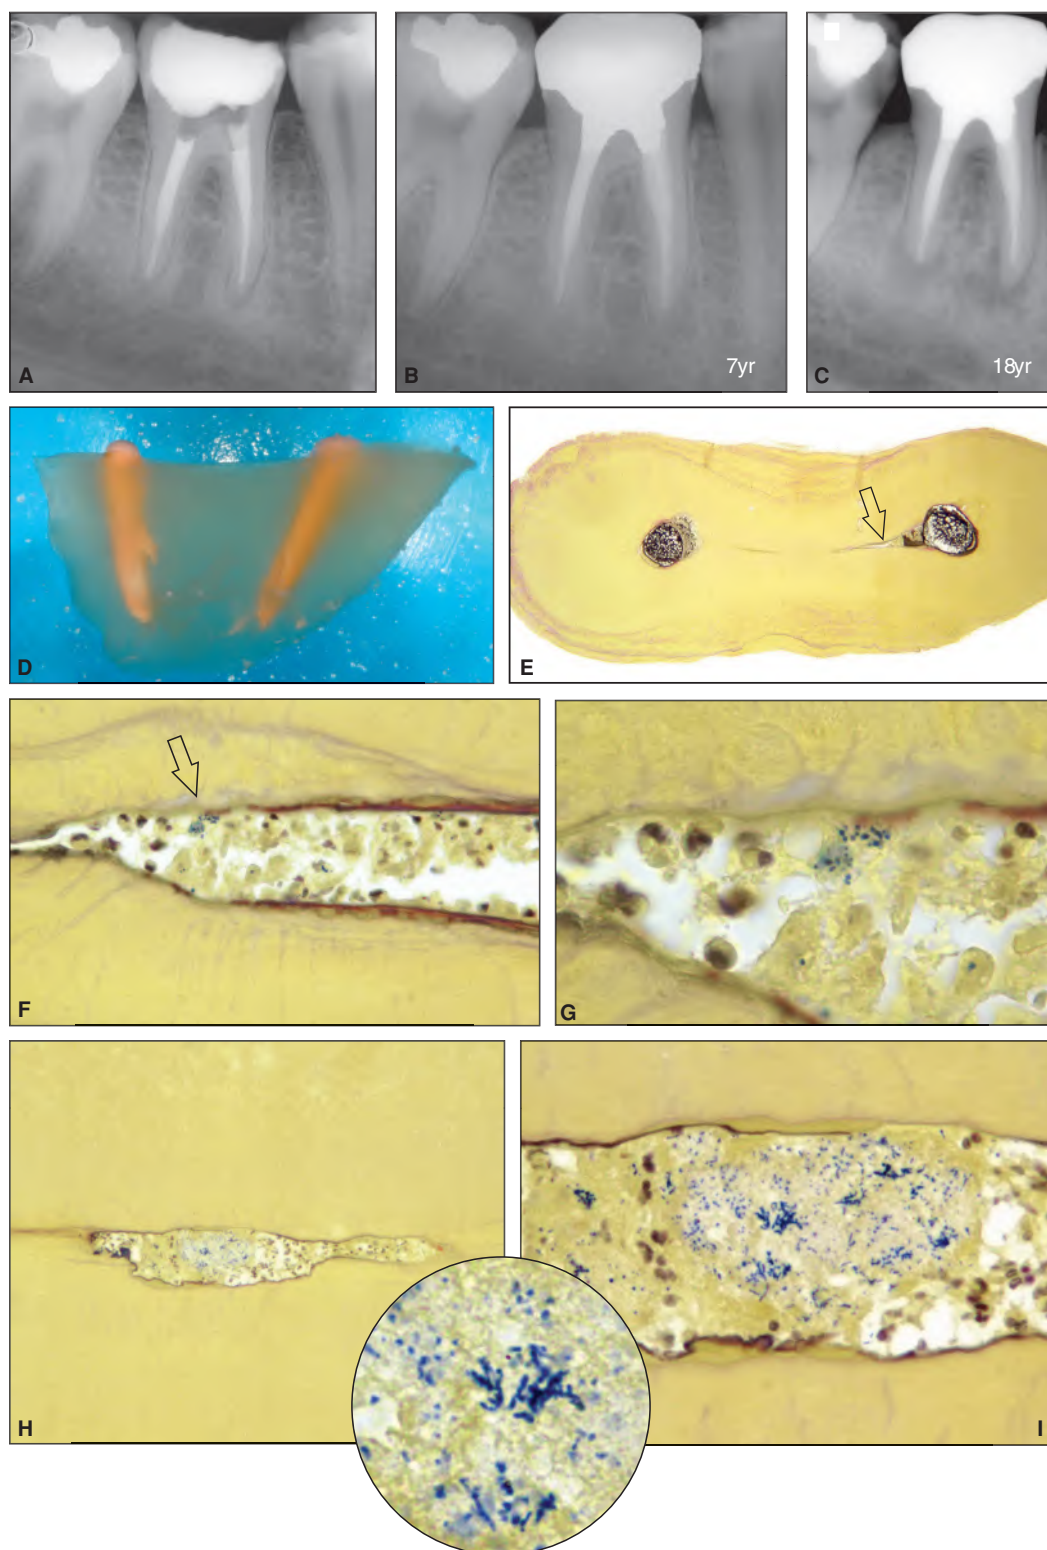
Mandibular molar with necrotic pulp. A. Post-obturation radiograph. B. Seven-year follow-up. Normal periapical conditions can be appreciated. C. Eighteen-year follow-up. Radiolucencies are now present on both roots. Endodontic surgery was performed. D. Apex of the mesial root after demineralization and immersion in clearing agent. E. Crosscut section taken approximately at the point indicated by the line in D. An isthmus is present (Taylor's modified Brown & Brenn, original magnification $\times 16$). F. Portion of the isthmus indicated by the arrow in E. Inflammatory cells in different state of conservation. A small bacterial aggregation can be noted (original magnification $\times 100$). G. High power view (original magnification $\times 400$). H and I. Section cut 1 mm coronally to that in E. Progressive magnifications of the expansion of the isthmus halfway between the two mesial canals show necrotic tissue colonized by bacteria and surrounded by inflammatory cells (original magnification $\times 100$ and $\times 400$. Inset, $\times 1000$).
